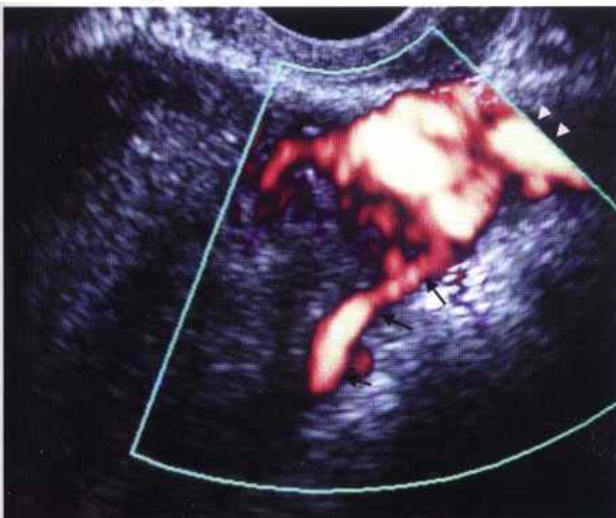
EVS. Power Doppler showing uterine artery (arrows) running alongside the uterine body.
